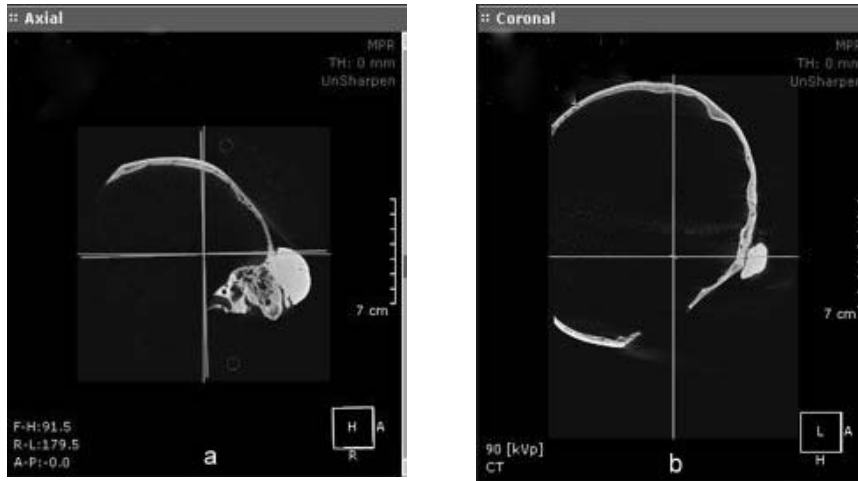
(a) CBCT axial view of the mastoid osteoma (R12, ♂, 55–60 year-old); (b) CBCT coronal view of the mastoid osteoma (R12, ♂, 55–60 year-old).
